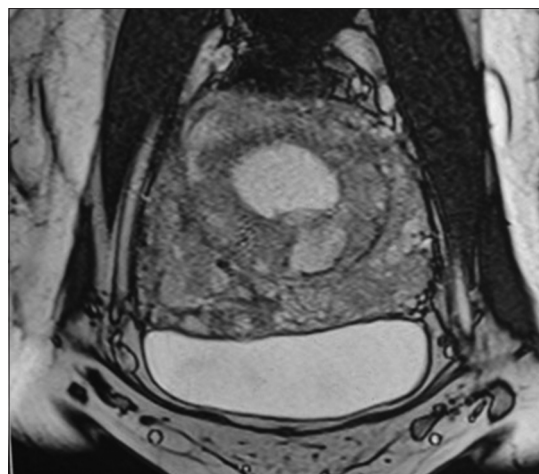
Coronal section T2-weighted: placenta percreta without interface between bladder and uterus (32 weeks gestation)
